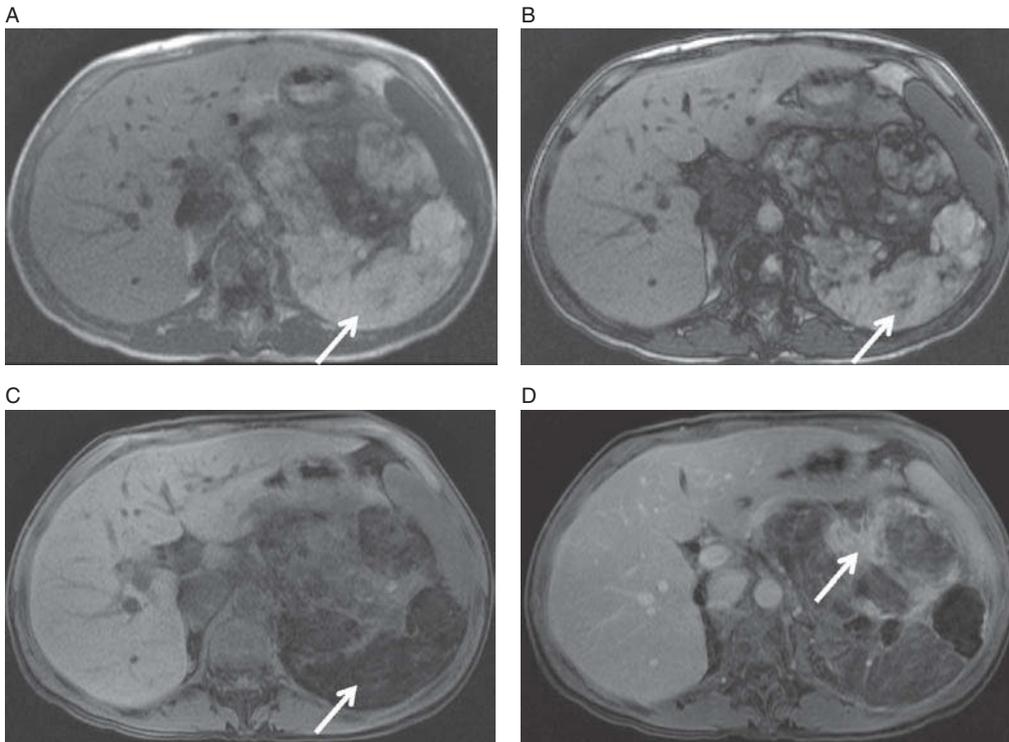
Tuberosclerosis with multiple AMLs. In-phase image (A) demonstrates numerous fat-containing lesions within the left kidney which demonstrate signal loss on out-of-phase image (B). Pre-contrast axial T1-weighted, fat-saturated image (C) demonstrates near-complete loss of signal due to fat saturation. Post-contrast image (D) shows the residual, normally enhancing renal parenchyma (arrow).
